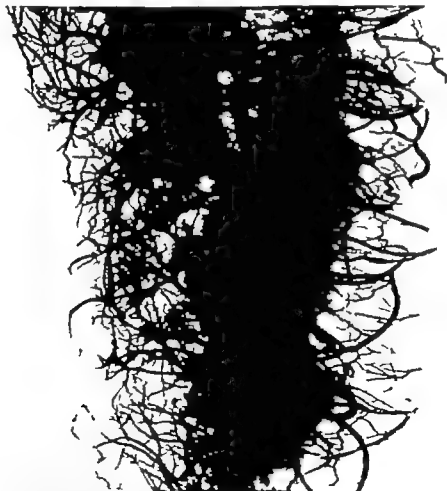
Radiograph of left ventricular free wall from a 17-year-old boy who died of renal failure as a complication of paroxysmal nocturnal hemoglobinuria. The epicardial surface is to the right. Note the large size of the Class B vessels and the subendocardial plexus, some of which measured 500 microns in diameter. There were a few small focal fibrotic lesions in the myocardium, but the coronary vessels were normal. (Enlarged $\times 3$)
